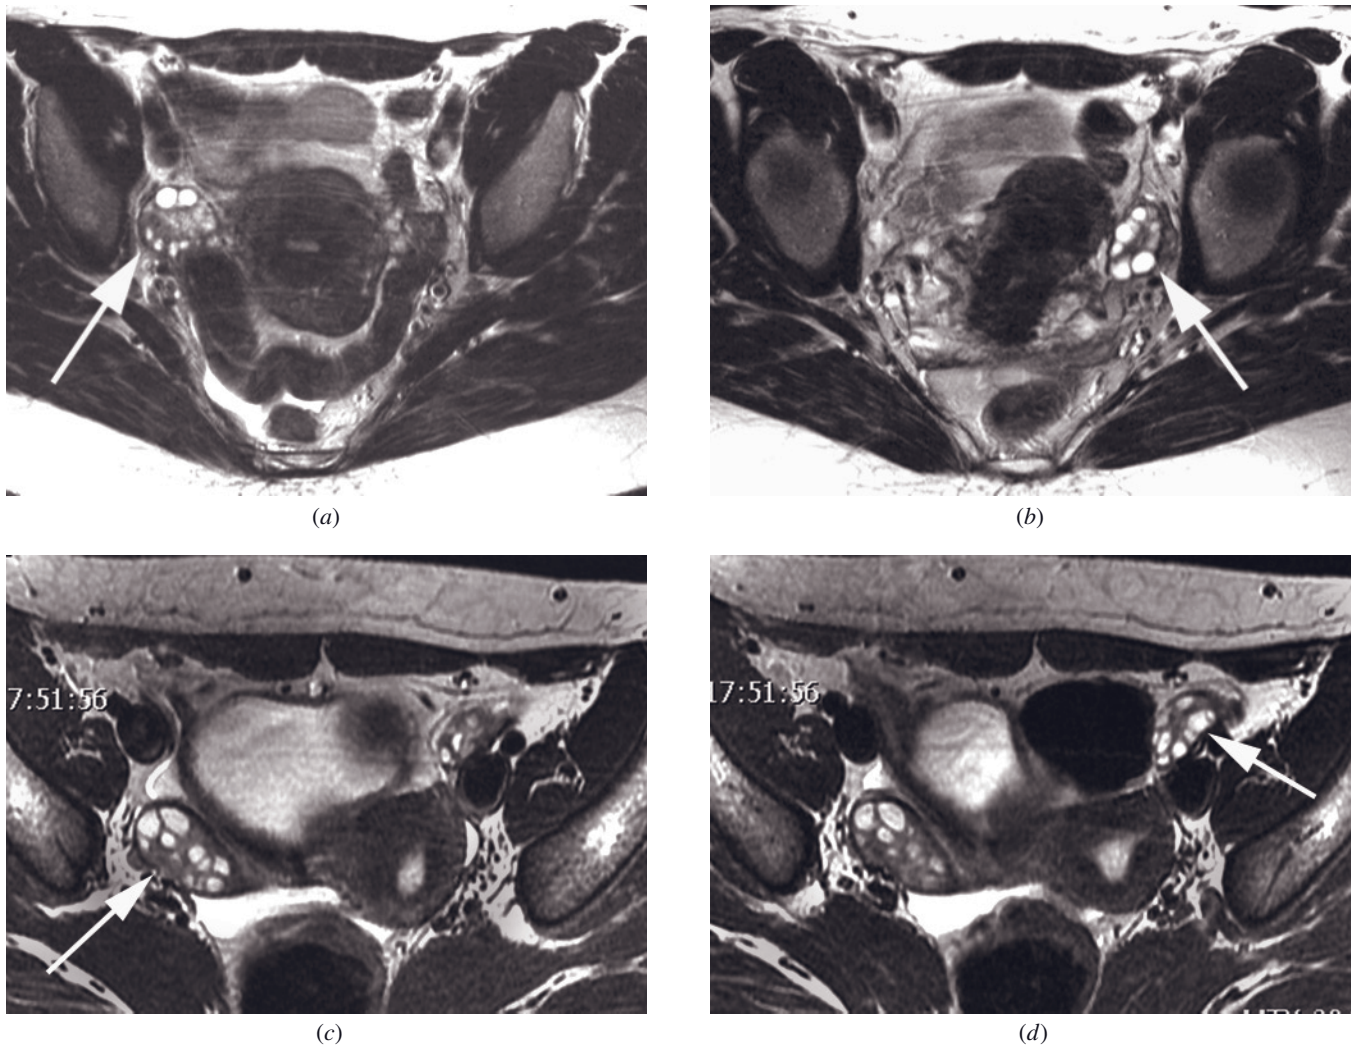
Normal ovaries. Transverse T2-weighted ETSE images demonstrate normal ovaries (arrows, *a, b*) with multiple small hyperintense follicles. Normal ovaries at 3 T. Transverse T2-weighted ETSE images demonstrate normal ovaries (arrows, *a, b*) with multiple small, hyperintense follicles.
